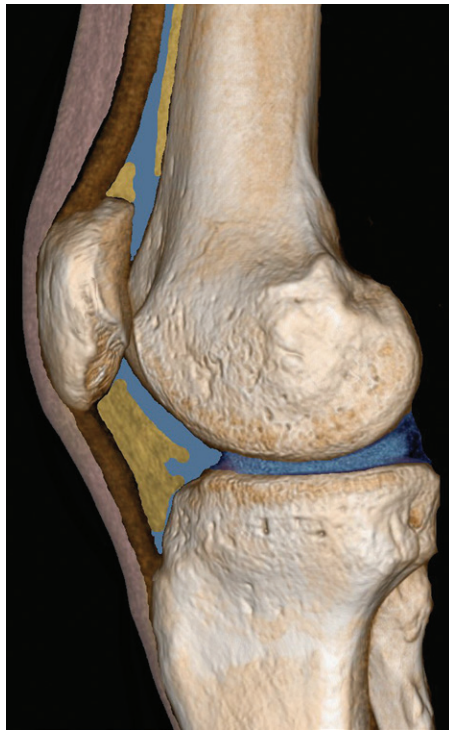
Layers of the anterior knee. Sagittal three-dimensional CT image of the knee shows that the anterior knee can be sequentially analyzed as a series of four layers of tissue. These four layers, from anterior to posterior, are the superficial soft tissues (pink), extensor mechanism (brown), extrasy-novial fat pads (yellow), and joint cavity (blue). By systematically evaluating these layers, the radiologist can identify the common pathologic conditions responsible for anterior knee pain.
